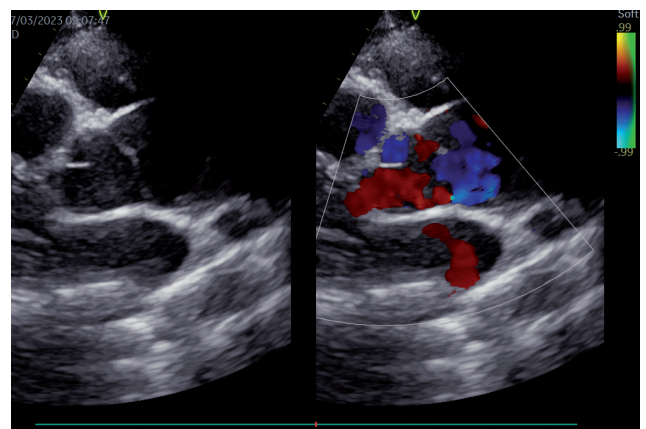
Parasternal long axis view – dilation of ascending aorta with entry level above right coronary sinus of Valsalva
